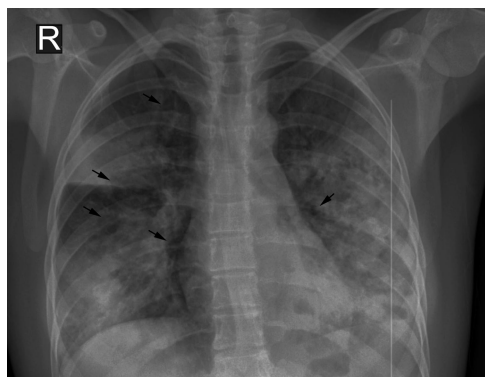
Chest radiograph on day 3 showing bilateral cavitary lung lesions (black arrows).
